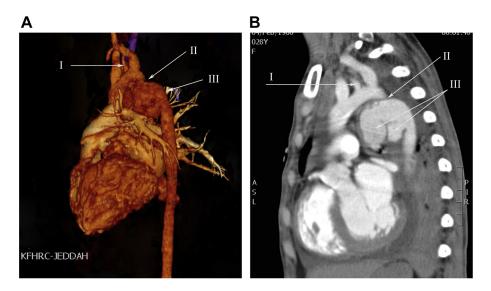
A, Preoperative volume-rendered reconstruction and (B) computed tomography angiography show (I) left vertebral artery (LVA), (II) aortic coarctation (AC), and (III) complex mycotic aortic aneurysm (MAA).
